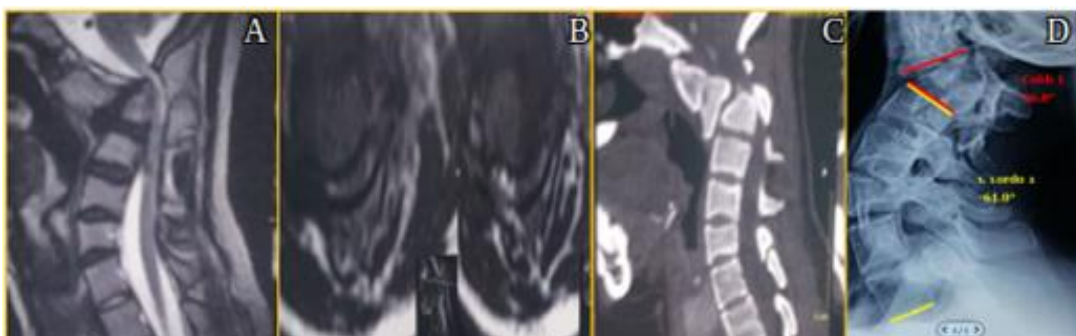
A and B – MRI sagittal and axial views showing severe medullar compression. C and D - CT scan and Xray showing congenital kyphosis.
